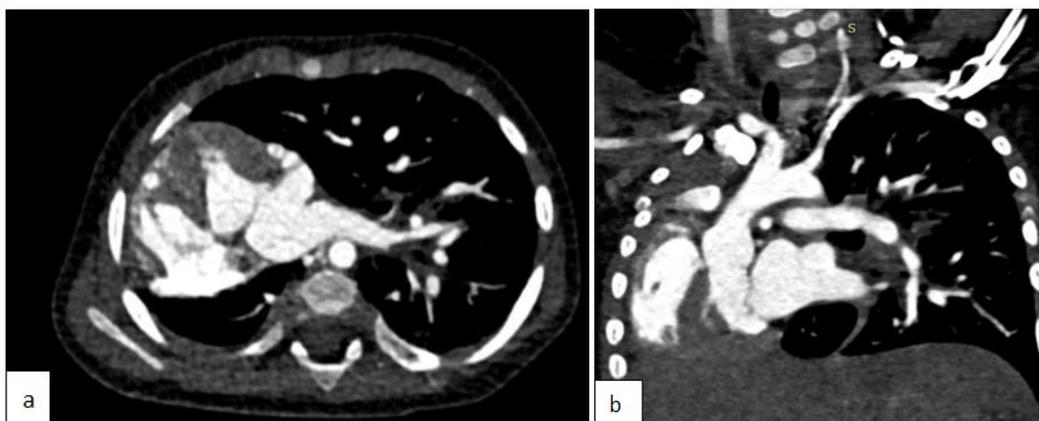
Contrast enhanced computed tomography of thorax ('a' axial section and 'b' coronal section) showing right pulmonary hypoplasia with dextrocardia
